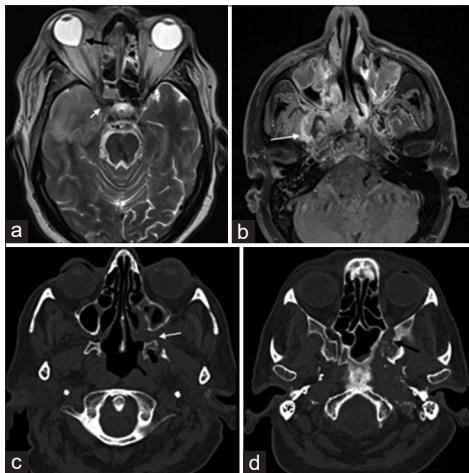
Mucormycosis with foraminal, deep space and skull base involvement. (a) Axial T2 weighted image shows hypointense lesion in right optic canal (white arrow) with tenting of posterior globe: “guitar pick sign” (black arrow), (b) Axial postcontrast fat suppressed T1 weighted image shows heterogeneously enhancing ill-defined lesion involving the right masticator space with involvement of sphenoid bone and clivus (white arrow), (c) Axial CT image shows soft tissue within left greater palatine foramen (white arrow) extending from left ethmoid air cells. (d) Axial CT images shows erosion of left greater wing of sphenoid and involvement of left pterygoid canal (black arrow). CT: Computed tomography
